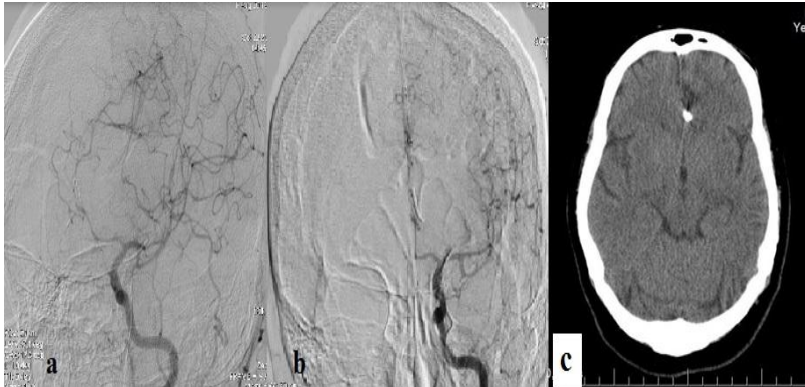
Postoperative lateral and A-P carotid angiogram revealing no residual filling of clipped distal anterior cerebral artery aneurysm. CT scan showing clipping of aneurysm (Case 2).
